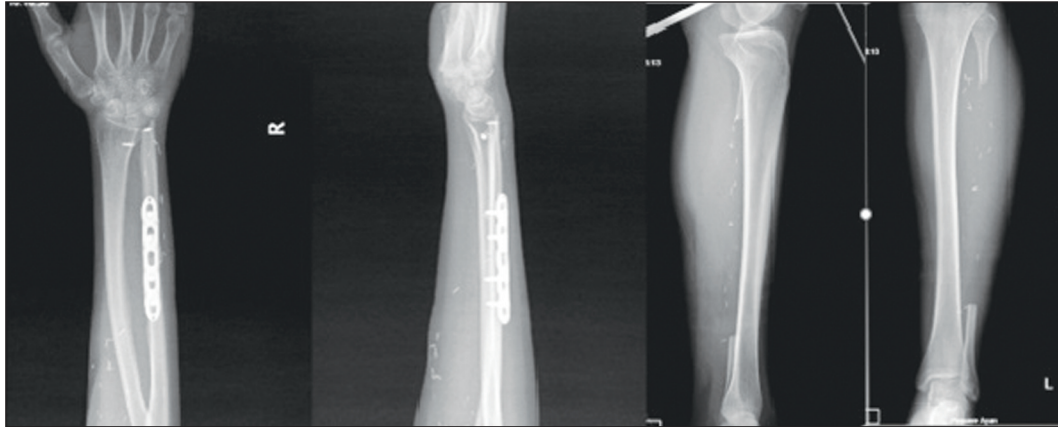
Direct X-rays of the patient who underwent a reconstruction by vascular fibula graft for cell bone tumor in the right ulna distal in the post-operative period.
